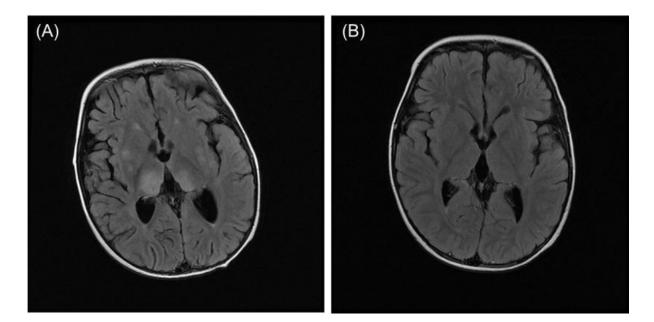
Brain imaging for patient BII:3. (A) Brain MRI of patient BII:3 aged 2.5 years during his first episode with status epilepticus and liver dysfunction demonstrates quite pronounced T2 hyperintensity of the thalami (R>L) and basal ganglia, suggestive of acute Leigh-like changes. (B) Brain MRI of patient BII:3 was repeated one year later when he presented with a further encephalopathic episode. The Leigh-like changes previously observed had resolved with no recurrence one year later. Mild cerebral atrophy is evident.
